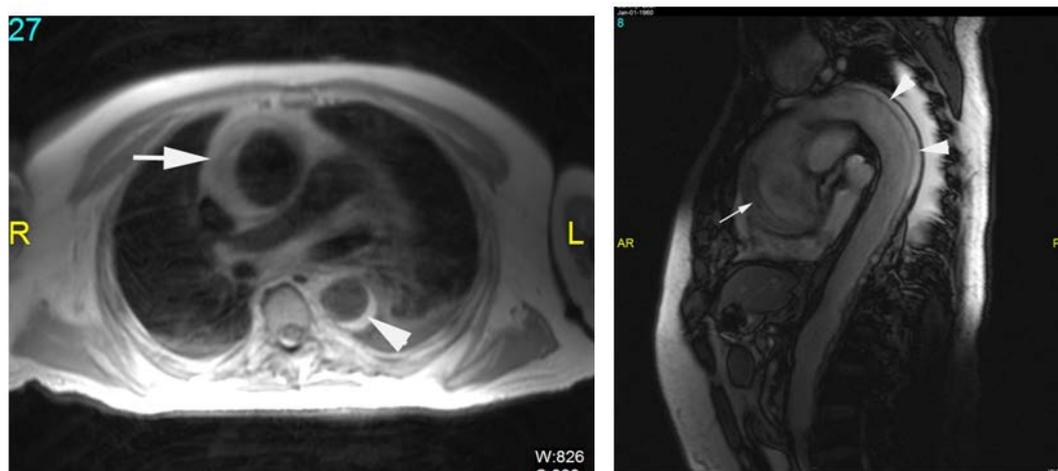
Axial MRI chest (Left) showing false lumen of ascending aorta (white arrow), and descending aorta (white arrow head); Sagittal MRI chest (Right) showing aortic dissection on the aortic root (white arrow) extending to the descending aorta (white arrow head)
